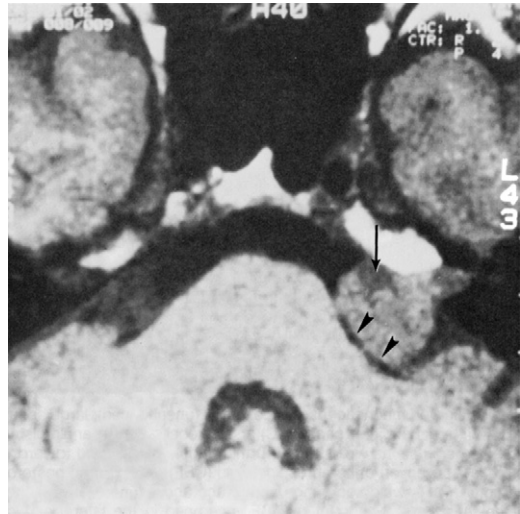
T₁-weighted magnetic resonance image without contrast, acoustic neuroma left side. The tumor flattens against the cerebellar peduncle (arrowheads). A small area of lower signal intensity represents a cystic area (arrow). The lesion can be followed into the internal auditory canal.
